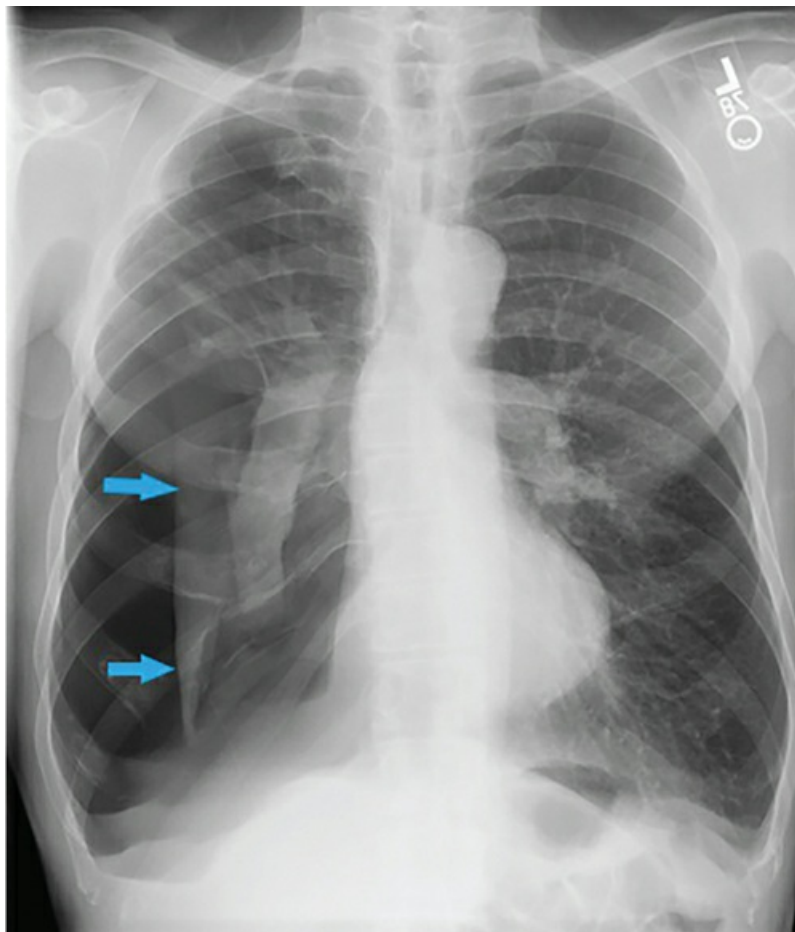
Chest radiograph of patient with right-sided spontaneous pneumothorax and underlying COPD. *Arrows* point to visceral pleural surface of lung. Beyond visceral pleura is air within pleural space. No lung markings can be seen in this region.
